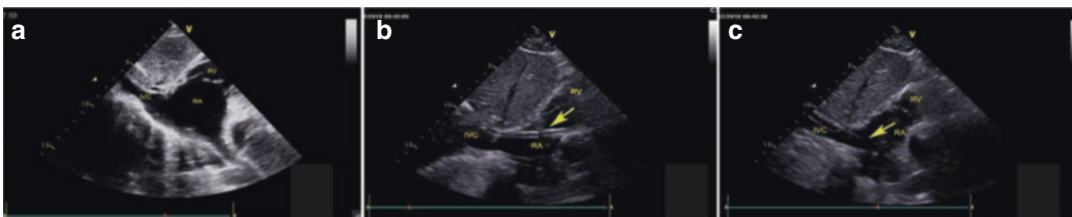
Echocardiography aids for precise placement of a venous cannula at ECMO cannulation. (a) subxiphoid view showing inferior vena cava (IVC), right atrium (RA)
